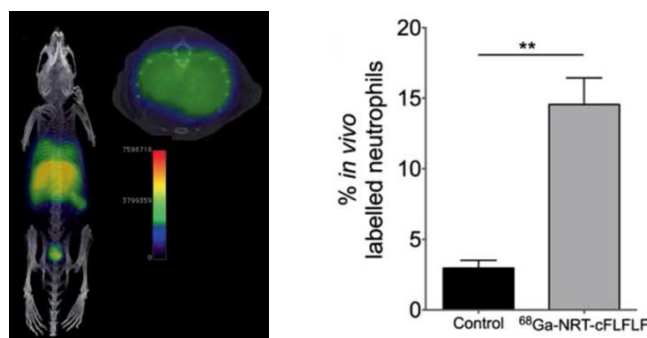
PET/CT imaging of neutrophils recruitment in the lungs and (right) percentage of labelled neutrophils *in vivo*.
